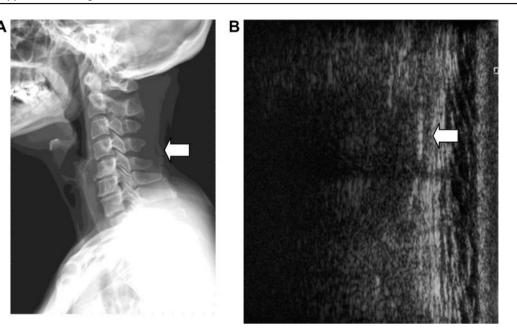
(A) X-ray and (B) ultrasound image of calcification of nuchal ligament (arrows).
